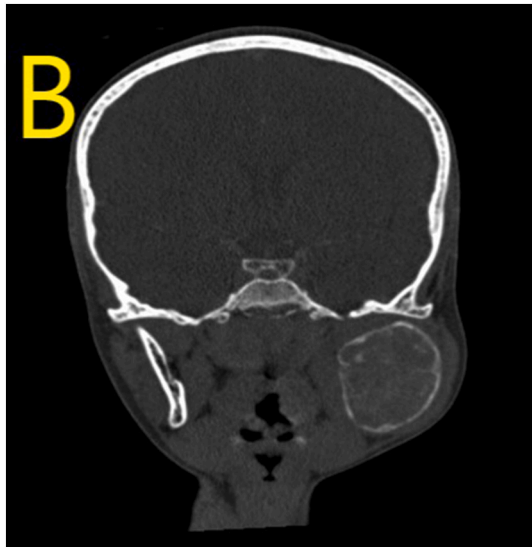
B. Coronal CT scans showing lucent lesion with buccal and lingual expansion in the left ramus/angle region.
